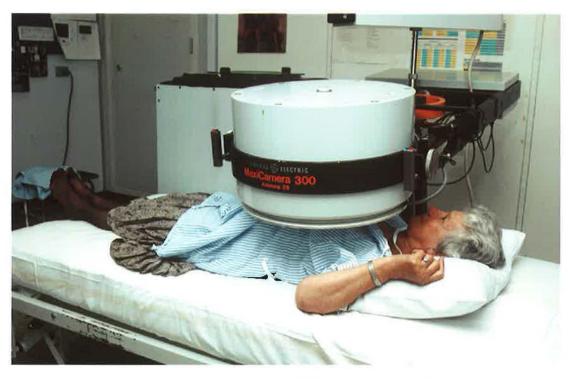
Lymphoscintigraphy; The patient being scanned under the gamma camera
